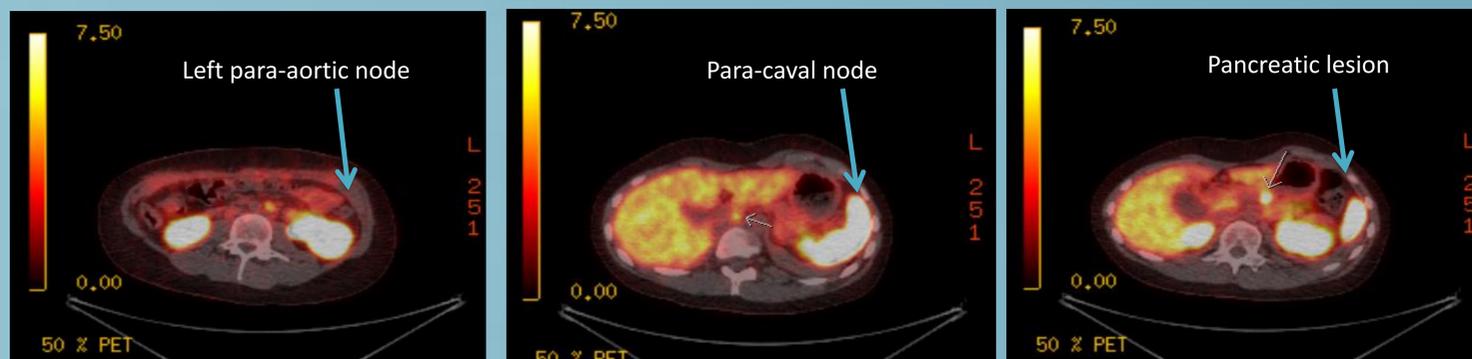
Gallium-68 DOTANOC PET-CT scan showing areas increased uptake as indicated
